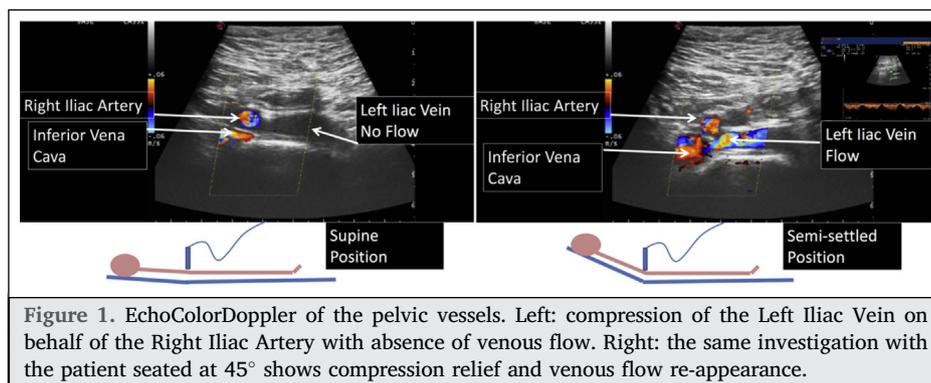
EchoColorDoppler of the pelvic vessels. Left: compression of the Left Iliac Vein on behalf of the Right Iliac Artery with absence of venous flow. Right: the same investigation with the patient seated at 45° shows compression relief and venous flow re-appearance.
